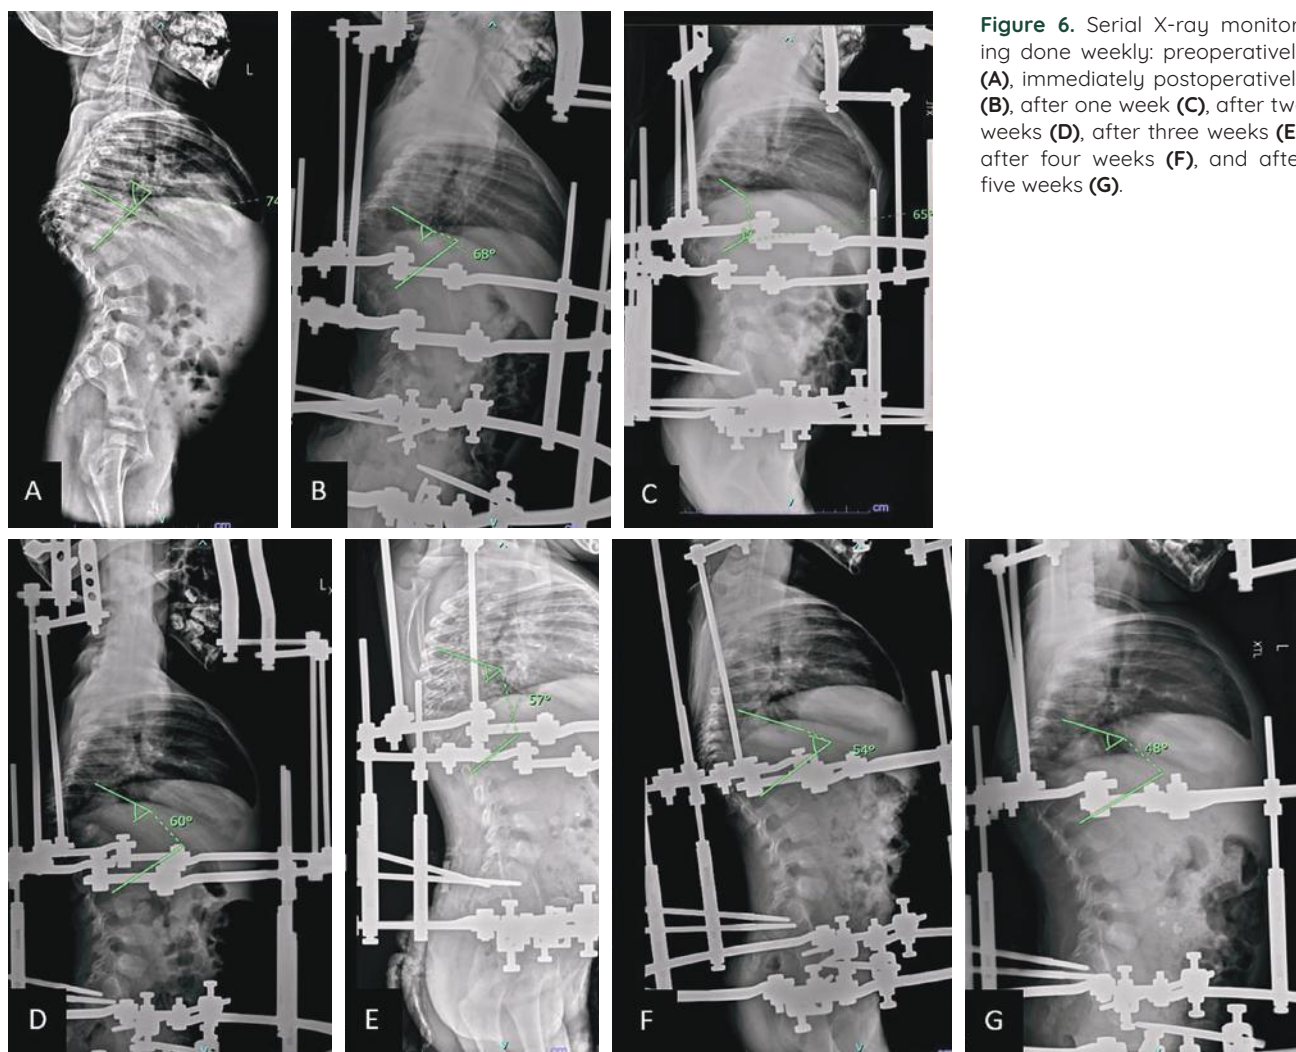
Serial X-ray monitoring done weekly: preoperatively (A), immediately postoperatively (B), after one week (C), after two weeks (D), after three weeks (E), after four weeks (F), and after five weeks (G).
